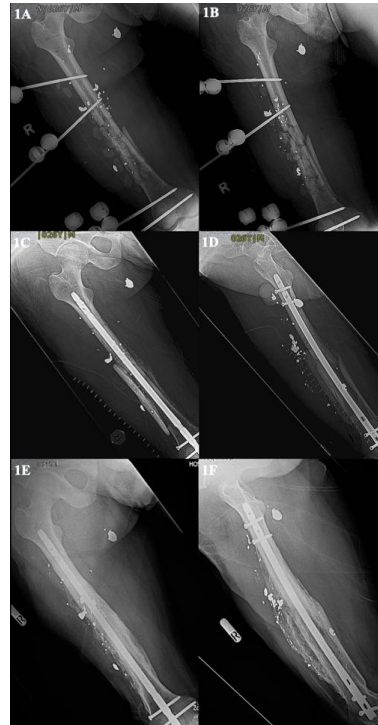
X-rays taken after external fixation and antibiotics cement beads (A,B), 1st stage Masquelet (C,D), fracture union (E,F).
